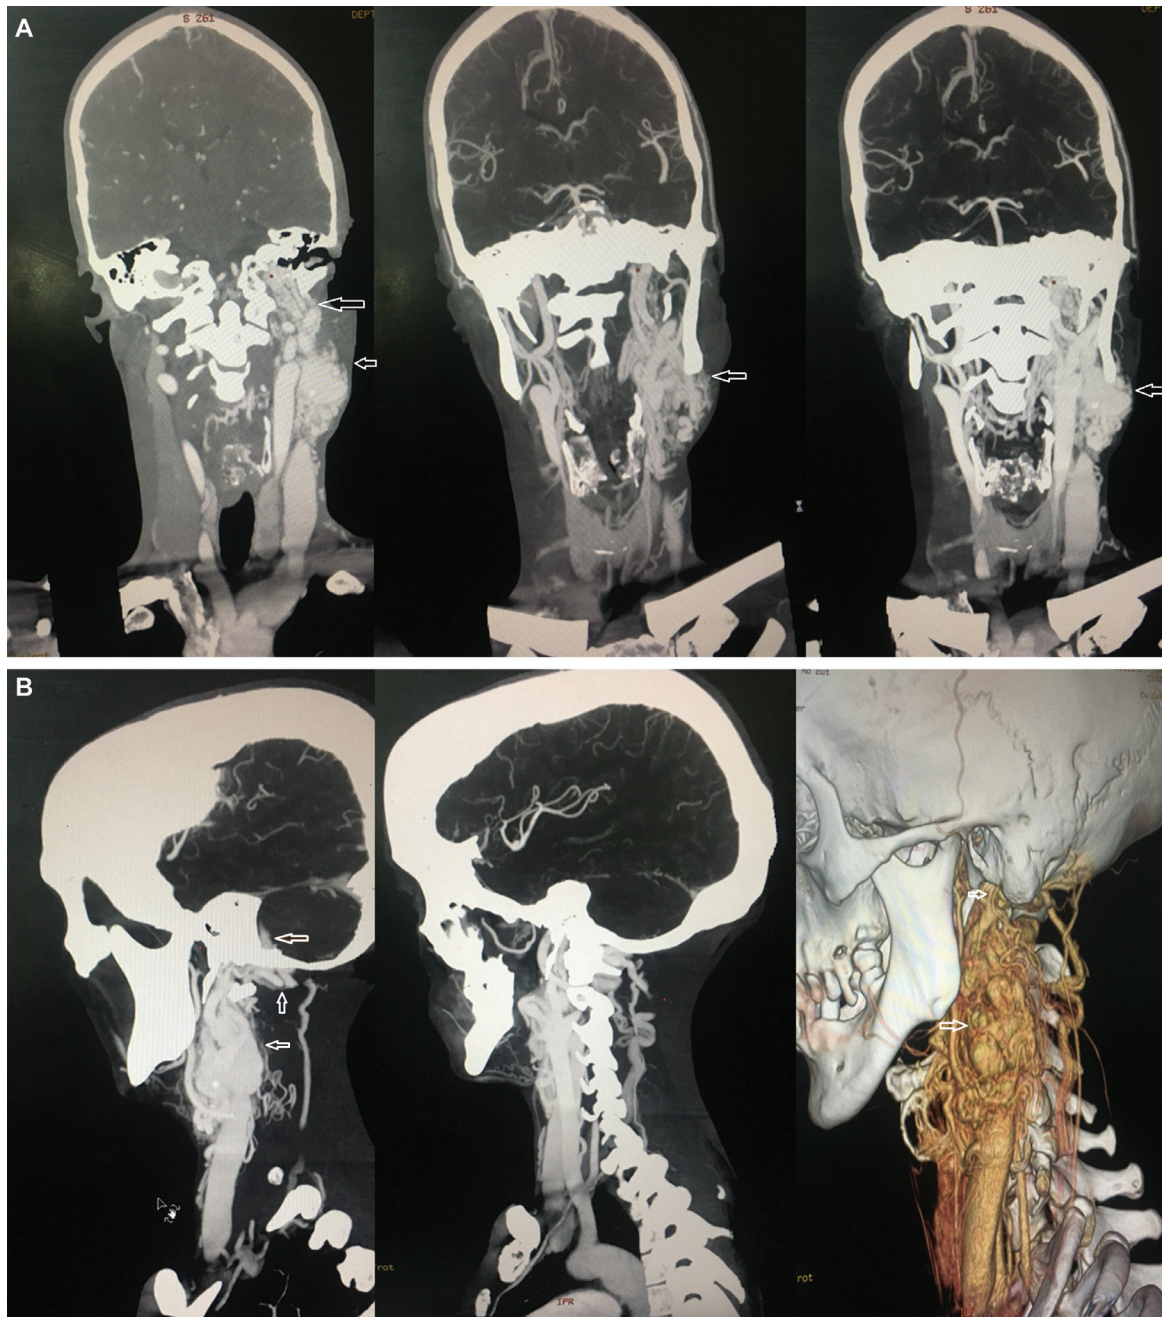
(A, B) Computed tomography angiography showing arteriovenous malformation in the neck and its extension into the cranial cavity with dural arteriovenous fistula (white arrows).
